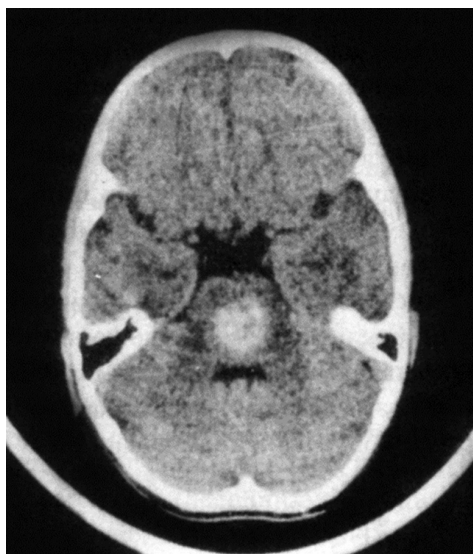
Medulloblastoma. CT scan showing medulloblastoma which is the most common posterior fossa tumor after astrocytoma (cerebellar) and the most common in under age 7 years.
